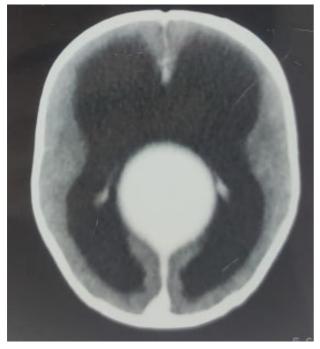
CT image of 6 month infant - increase in size of Aneurysm of vein of Galen & dilated lateral ventricles
